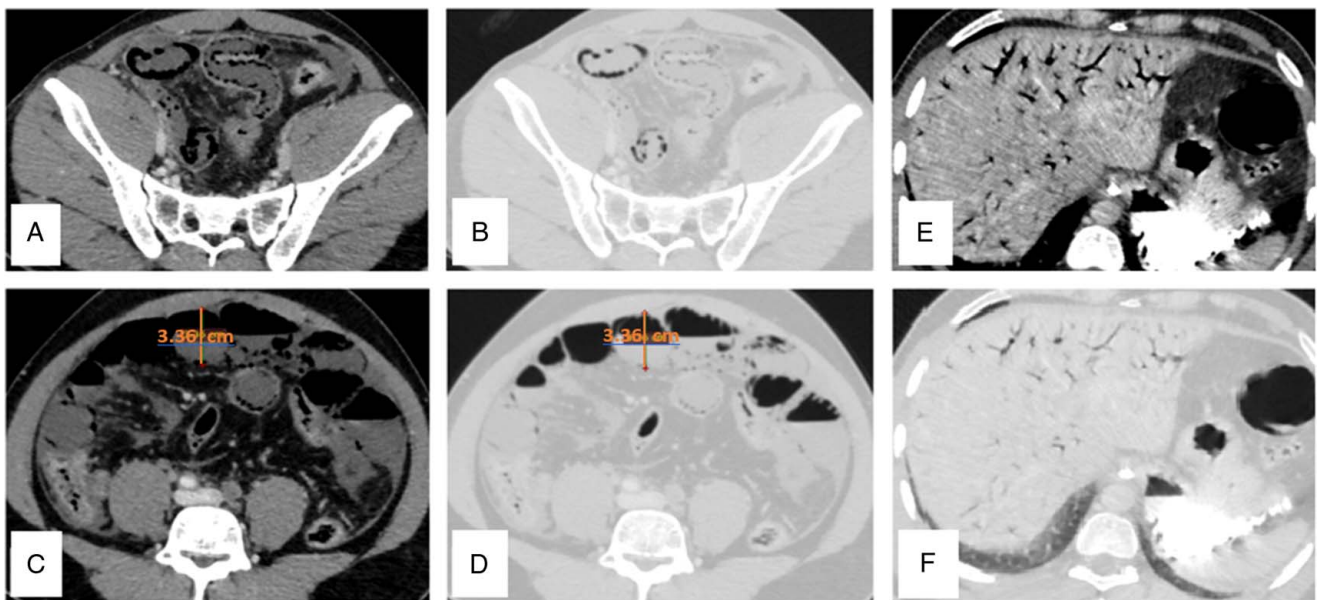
Axial contrast-enhanced computed tomography images in soft tissue window (A, B) show the presence of air attenuating areas along the small bowel walls confirmed by corresponding dark areas in lung window images (C, D) confirming the diagnosis of 'pneumatosis intestinalis.' Axial contrast-enhanced computed tomography images in soft tissue and lung windows (E, F) demonstrate the presence of fine linear branching air attenuating areas in the liver in continuation with portal veins and extending up to the periphery of the liver, suggestive of 'portal venous gas.'
